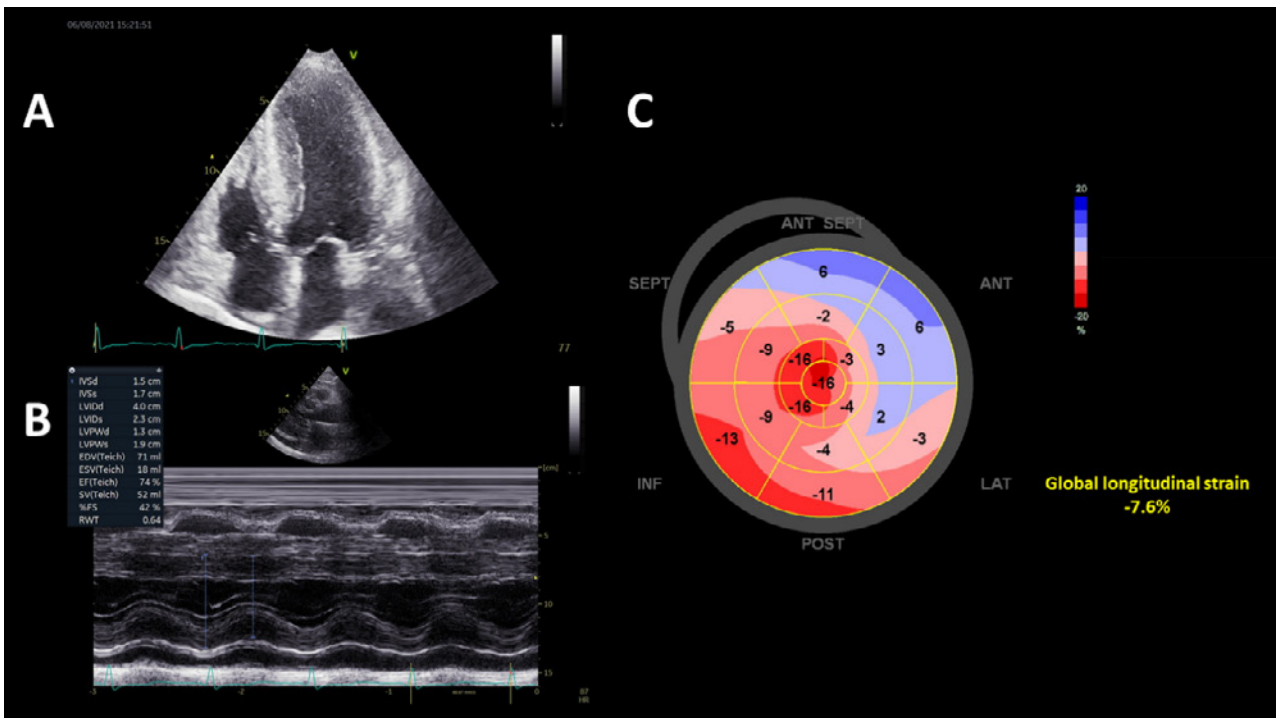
Panel A shows marked left ventricular hypertrophy in apical 4 chamber view. Panel B shows normal ejection fraction in this patient by M-mode. Bullseye mapping of longitudinal strain (panel C) shows diffusely decreased strain in Case 2 (ANT SEPT = anteroseptal wall; SEPT = septal wall; INF = inferior wall; POST = posterior wall; LAT = lateral wall; ANT = anterior wall of LV).
